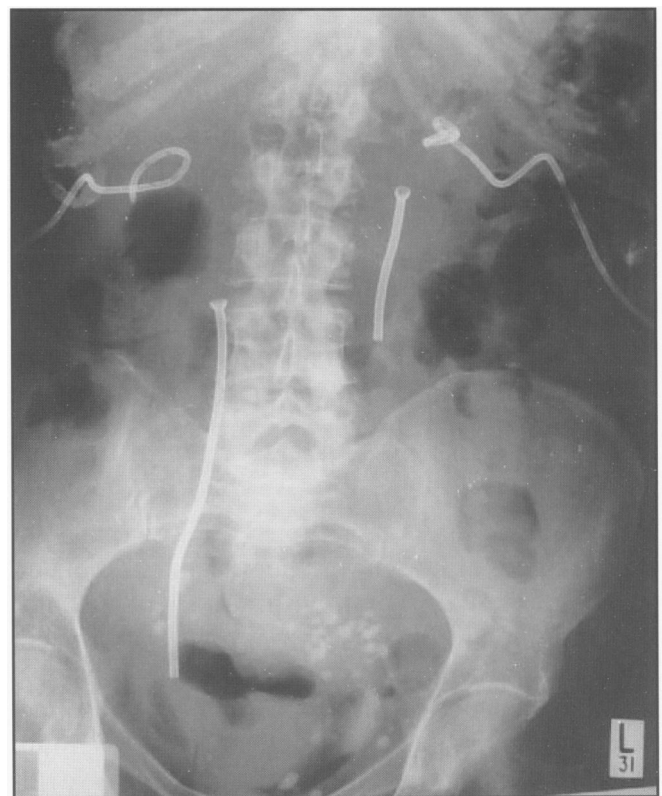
Post procedure radiograph demonstrates position of the bilateral *Memokath* ureteric stents prior to removal of the nephrostomy drains.
